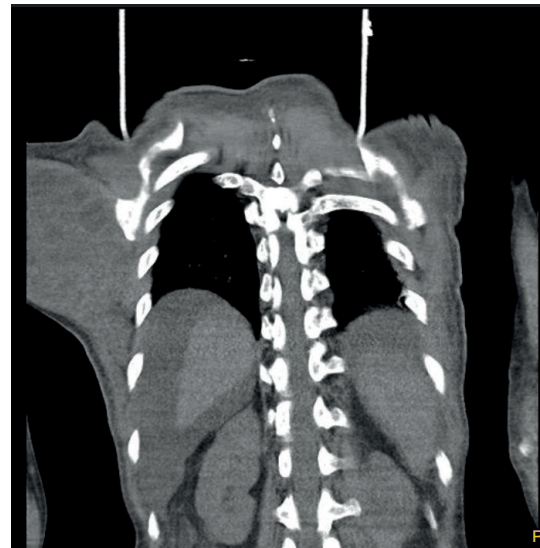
Pre-operative CT show cystic swelling (marked with arrow) with fluid in right axilla separate from chest wall.
